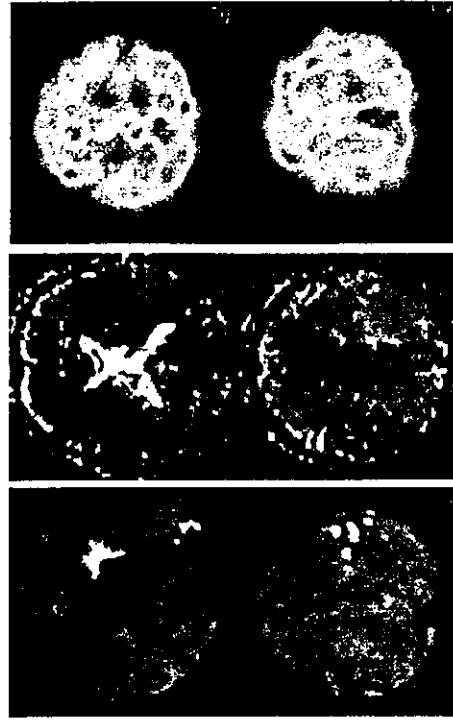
Neuroradiological assessment before and after the plasmapheresis in Patient 3. A: Before the extracorporeal double filtration plasmapheresis (EDFP), MR angiography revealed severe stenosis in the middle cerebral artery (arrow) and diffusion/perfusion mismatch was observed in diffusion-weighted image (DWI), perfusion image (PI), and  $^{99m}\text{Tc}$ -HMPAO-SPECT. B: Twenty hr after the EDFP, improvement of distal opacification of the middle cerebral artery was demonstrated by MR angiography (arrow). A significant CBF improvement was observed both in  $^{99m}\text{Tc}$ -HMPAO-SPECT and perfusion image (PI), and consequently a diffusion/perfusion mismatch was not observed.
